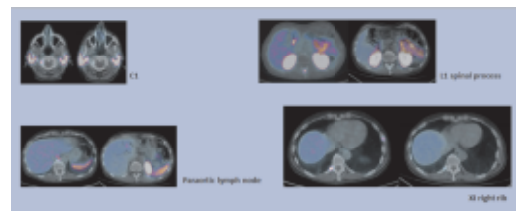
Pre and post-RT PSMA-PET in some irradiated targets.
